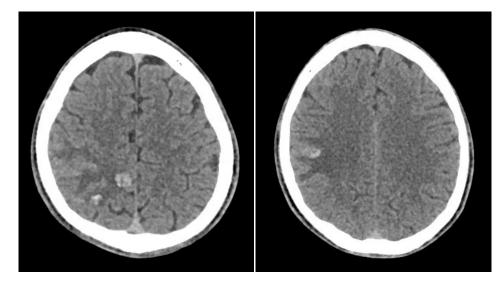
Computed tomography scan of the head (June 2023) showing multiple hyperdense lesions in the right temporoparietal and frontal regions.
